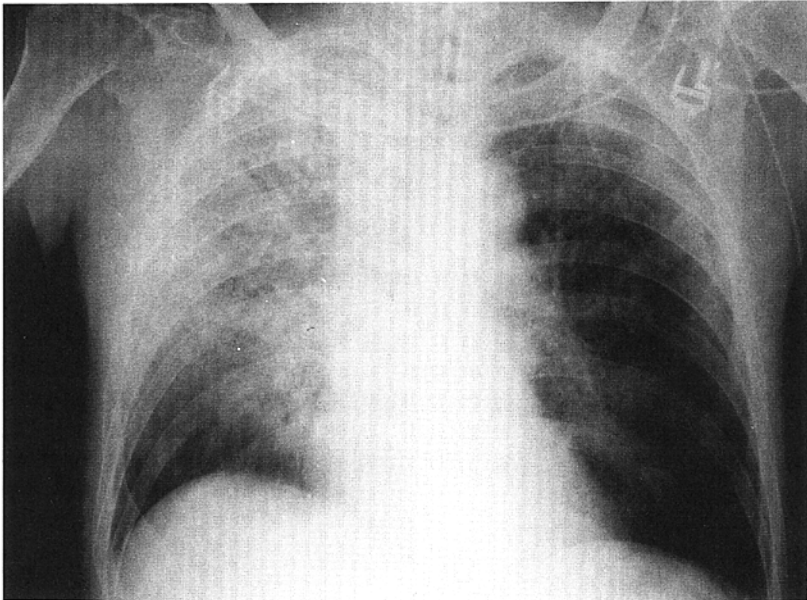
A chest radiograph of a 62-year-old male with advanced emphysema, showing a right upper-lobe consolidation with "honeycomb" appearance.
